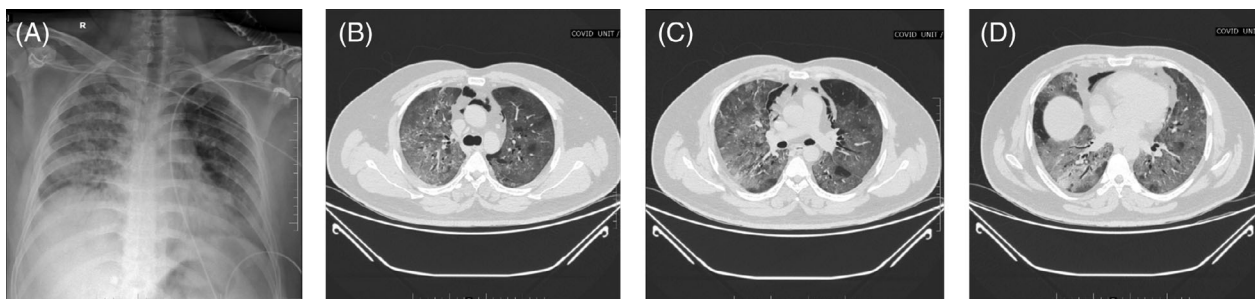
(A–D) Chest x-ray and computed tomography of the thorax done on the day the patient was tested COVID positive (27 September)
